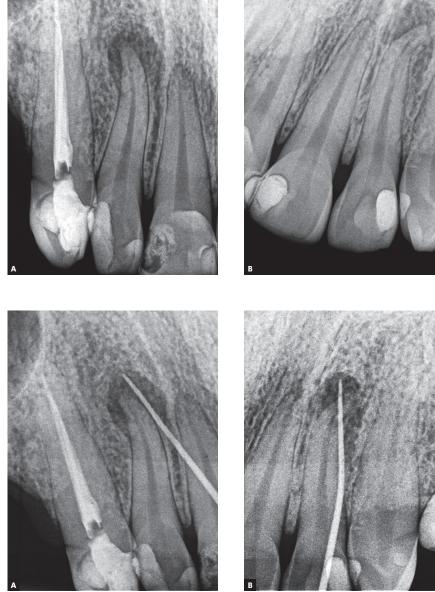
Radiographic screening.
